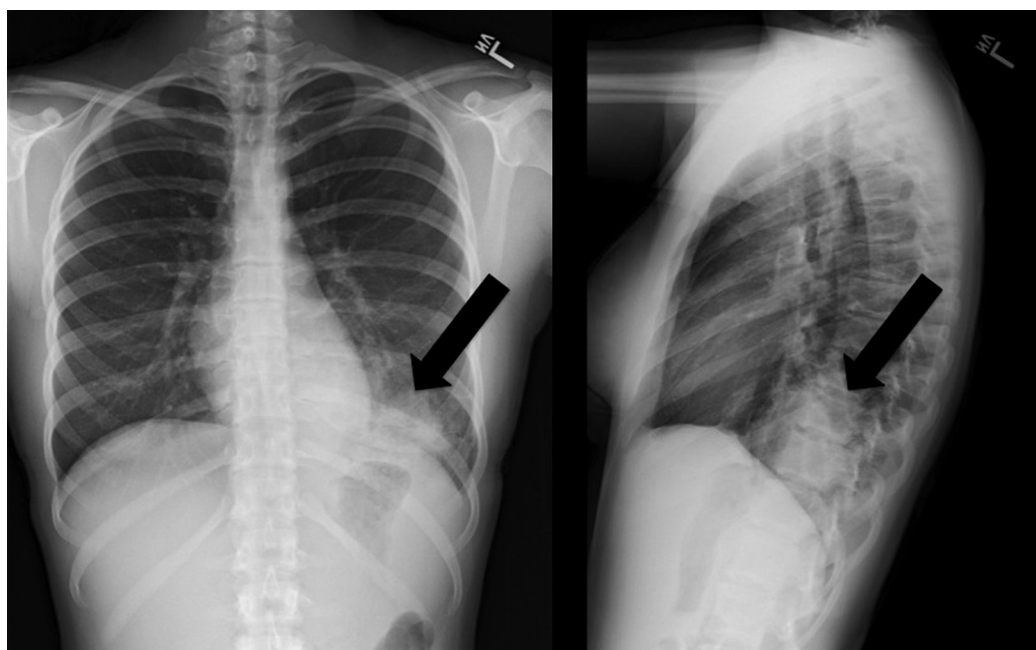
Anterior-posterior and lateral chest radiographs showing a left lower lobe pulmonary sequestration (*bold arrow*) in a 15-year-old girl.
